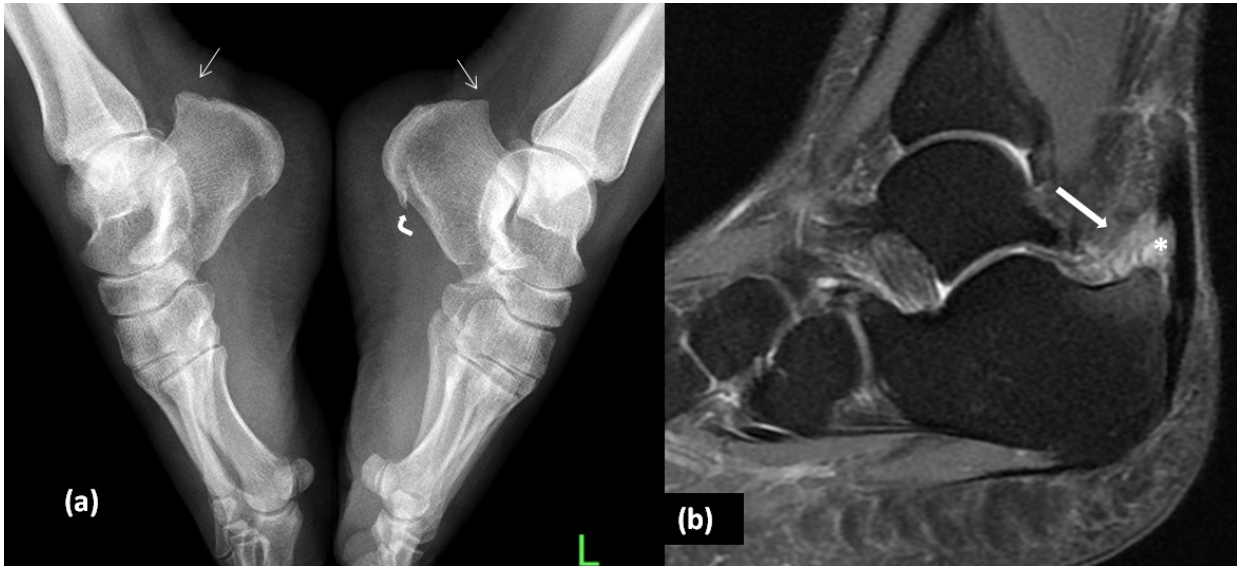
Lateral radiograph (a) of both feet of a 37-year-old female patient complaining of posterior ankle pain on the right side demonstrates bilateral Haglund deformity (arrows) and a calcaneal spur (curved arrow) on the left side. The sagittal STIR MR image of the right ankle (b) demonstrates the retrocalcaneal synovitis (thick arrow), associated bone marrow oedema at the superior aspect of the calcaneus and partial thickness tear (asterisk) at the distal Achilles tendon.
